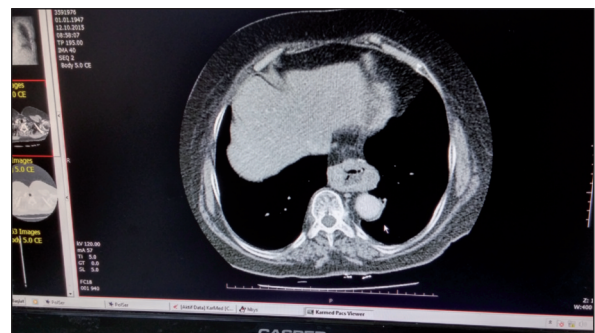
CT image, Axial view.
